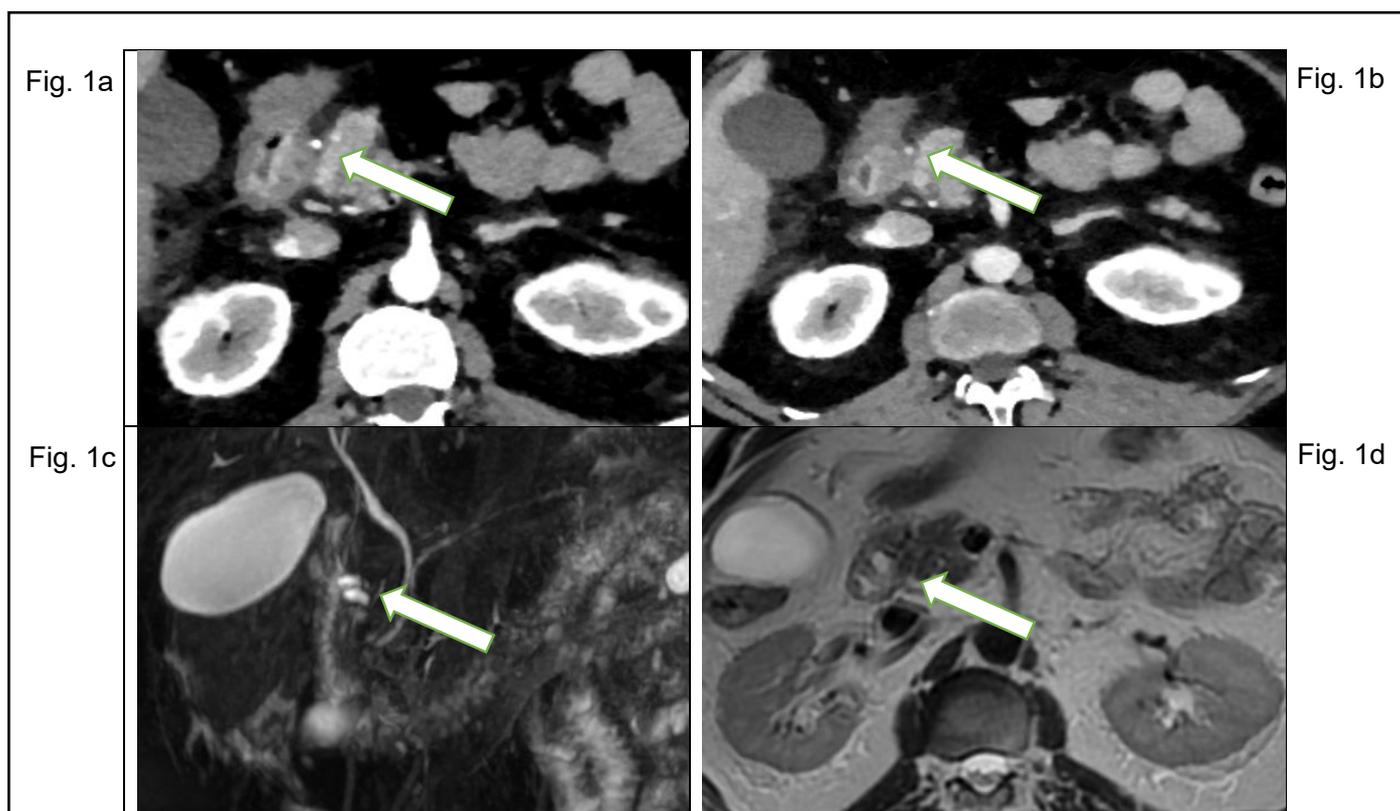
a and b. Contrast-enhanced CT of abdomen (axial section) shows a thickened duodenal wall and cysts within it determining lumen narrowing; also seen is the leftward displacement of a normal appearing pancreaticoduodenal-artery (arrow), a key imaging finding to differentiate it from groove pancreatic carcinoma. c and d. MR Imaging. Paraduodenal cystic lesions are well seen on MRCP and T2-weighted axial MR image (arrow); smooth distal CBD stricture is also seen, along with non dilated pancreatic duct.
